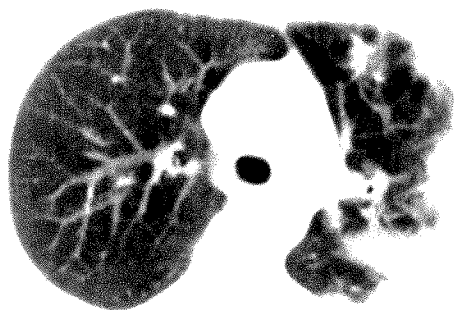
CT scan shows unilateral peripheral air-space consolidation. Patient had chronic eosinophilic pneumonia and coexistent bronchiolitis obliterans organizing pneumonia.
